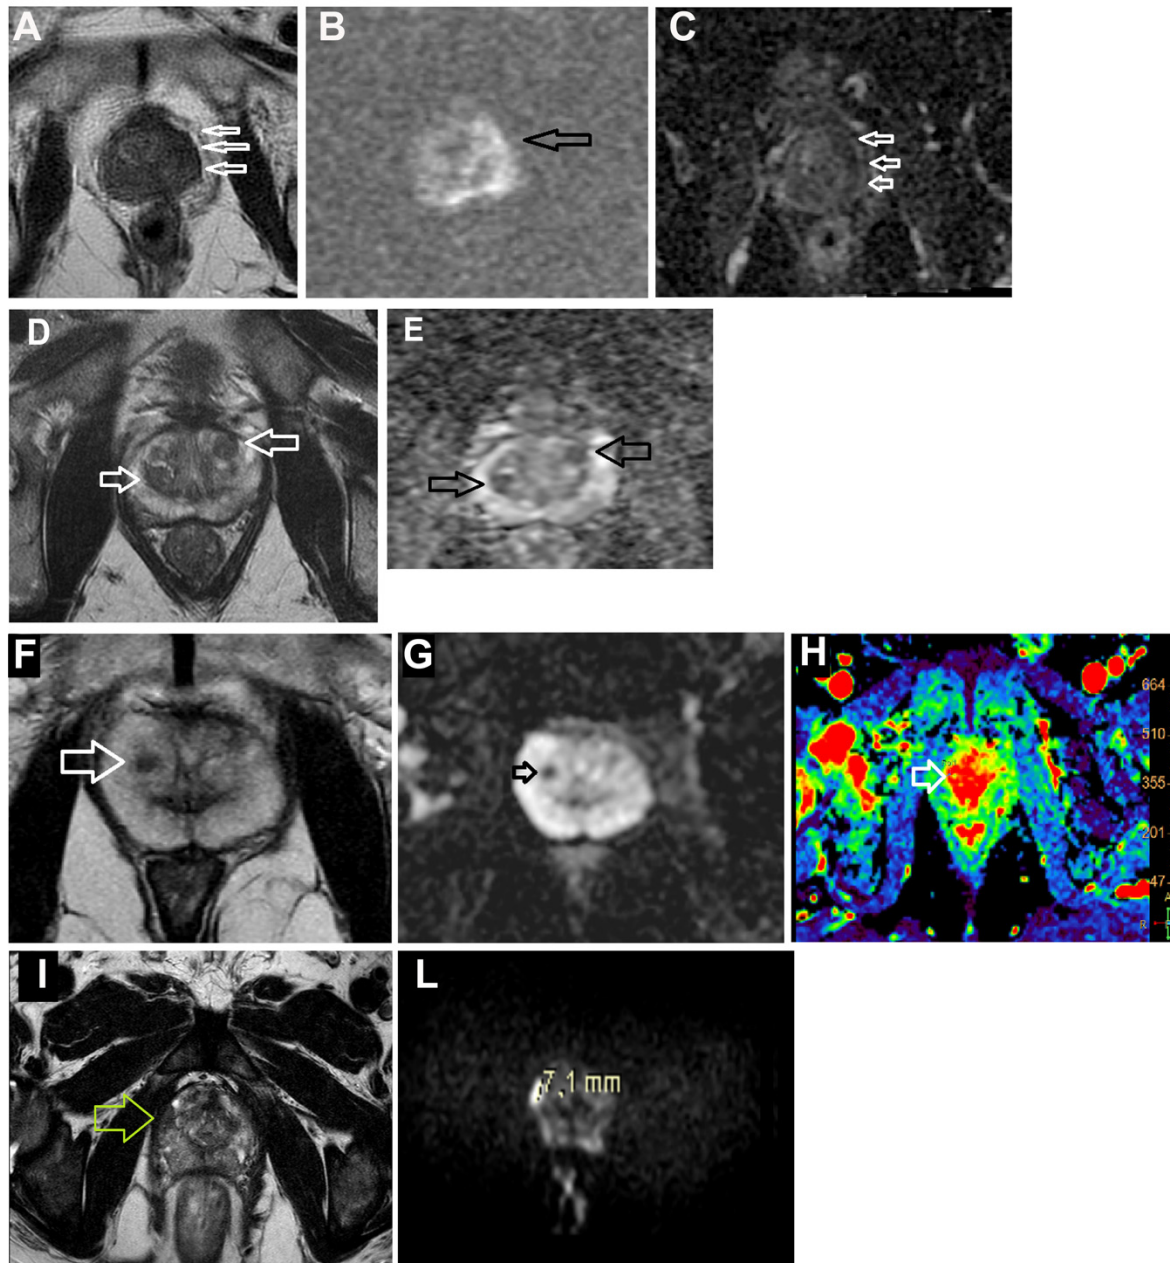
Examples of mpMRI with PIRADS 4 score. (A-C) A 68-year-old patient with a serum PSA level of 9 ng/ml and fusion biopsy showing ISUP 3 in the random cores. (A) Axial T2WI shows a 13 mm area of decreased signal intensity in the left anterior transition zone (white arrows) with (B) high b -value DWI (1500 s/mm^2 , black arrows) and (C) ADC restricted diffusion (white arrows). (D-E) A 63-year-old patient with a serum PSA level of 4.44 ng/ml and fusion biopsy showing ISUP 1 in the random and fusion cores. (D) Axial T2WI shows 2 areas of decreased signal intensity in the left anterior and in the right posterior transition zone (white arrows) with (E) ADC restricted diffusion (black arrows). (F-H) A 63-year-old patient with a serum PSA level of 10.6 ng/ml and fusion biopsy showing ISUP 3 in the random cores. (F) Decreased signal in axial T2WI (white arrow) and (G) axial ADC map demonstrates restricted diffusion (black arrow). (H) Color perfusion map created using postprocessing software for dynamic contrast enhanced MR imaging acquisition demonstrates suspicious perfusion kinetics for prostate cancer. (I-L) A 70-year-old patient with a serum PSA level of 15 ng/ml and fusion biopsy showing ISUP 3 in the fusion cores. (D) Axial T2WI shows an area of decreased signal intensity in the right peripheral zone (arrows) with (E) high b -value DWI (1500 s/mm^2).
